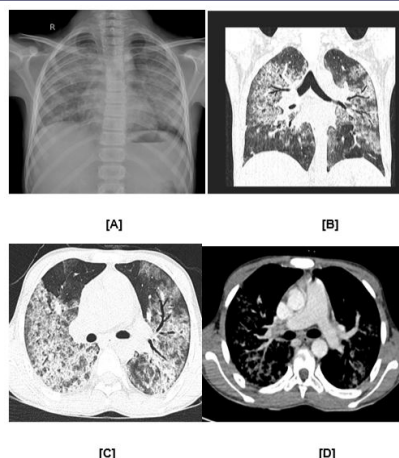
Pneumocystis jirovecii pneumonia (PJP) in 18-year-old HIV male with a CD4 count 20 cells/ul. The chest radiograph shows perihilar ground-glass appearance in the shape of bats-wings. Computed tomography (CT) in showing foci of consolidation and interlobular septal thickening due to organized inflammatory infiltrate and ground-glass attenuation with a geographic or mosaic distributions.
